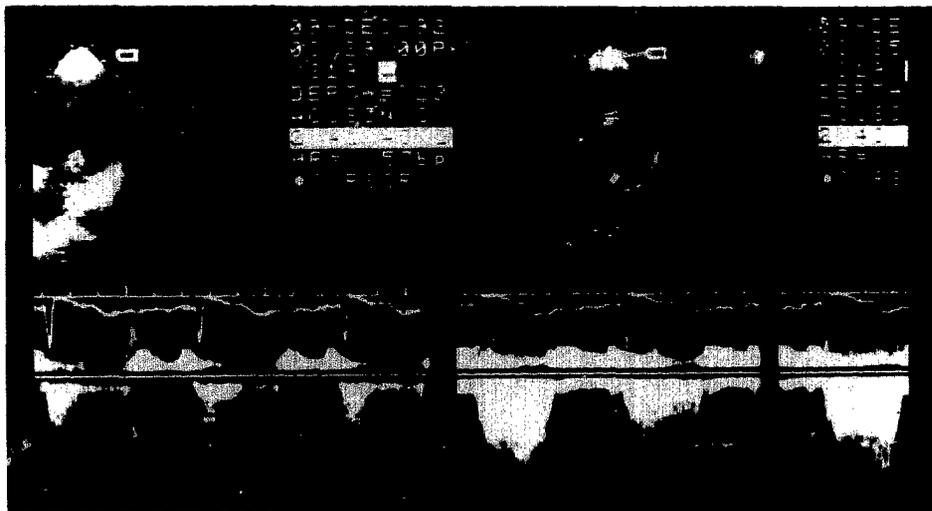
Original continuous wave Doppler recording of the regurgitant velocities in mitral regurgitation is too indistinct to determine peak velocity at the baseline study (left). After contrast enhancement (right), the increased intensity of Doppler signal provided clear envelopes and therefore quantitative analysis.
